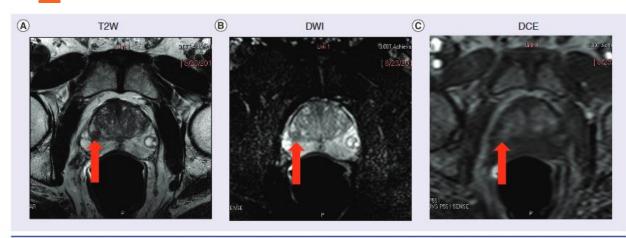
Multiparametric MRI of prostate from 66-year-old male with history of Gleason score 3 + 4 = 7 on systematic 12-core transrectal ultrasound-guided prostate biopsy, subsequently upgraded to Gleason score 4 + 4 = 8 following multiparametric MRI and fusion-guided targeted biopsy. Low signal intensity on T2W, restricted diffusion on DWI and focal enhancement on DCE reveal 0.7 cm lesion on right mid transitional zone (arrows).
